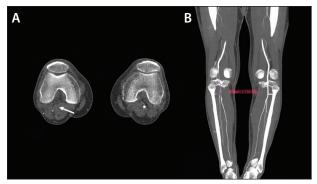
Preoperative CTA: thrombotic occlusion of the popliteal artery (A); maximum intensity projection reconstruction showing no signs of atherosclerosis in the femoropopliteal tract, with 7-cm-length occlusion of the right popliteal artery and quite good opacification of the fibular and posterior tibial artery due to genicular revascularization (B).
